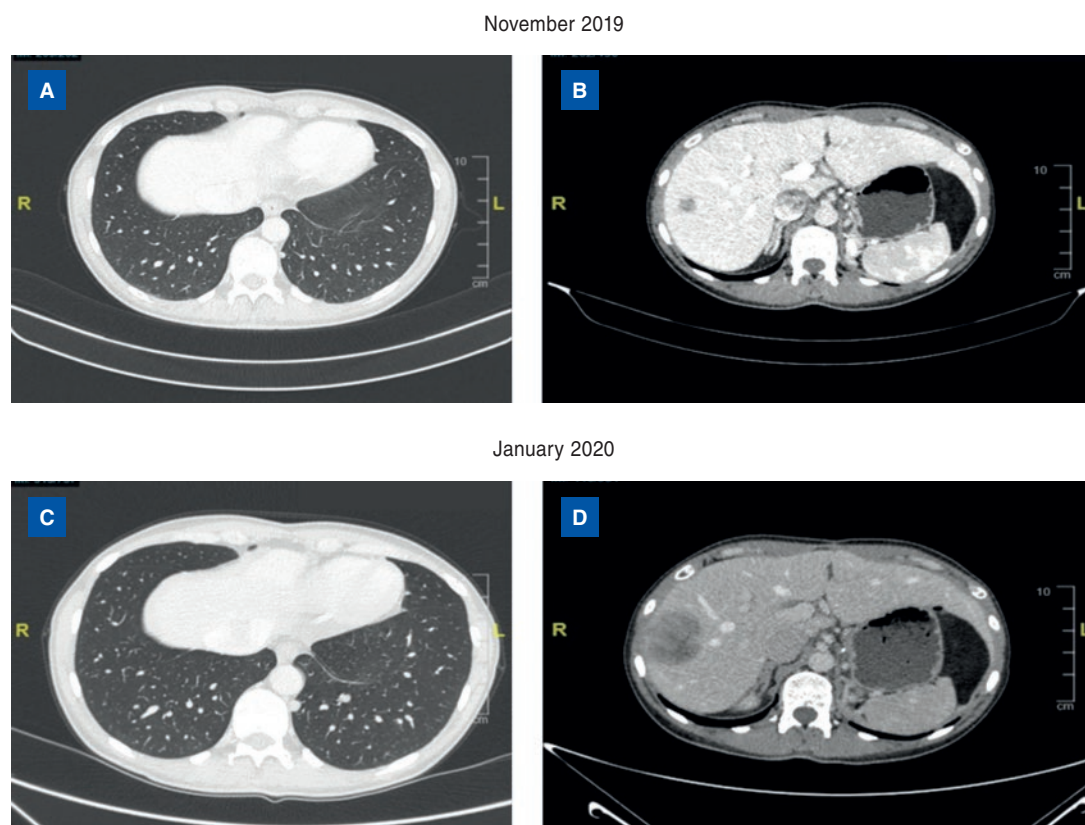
“Watch and wait” from November 2019 to January 2020. Computed tomography scan of nodules in the lungs (A, C) and mass in the liver (B, D).
